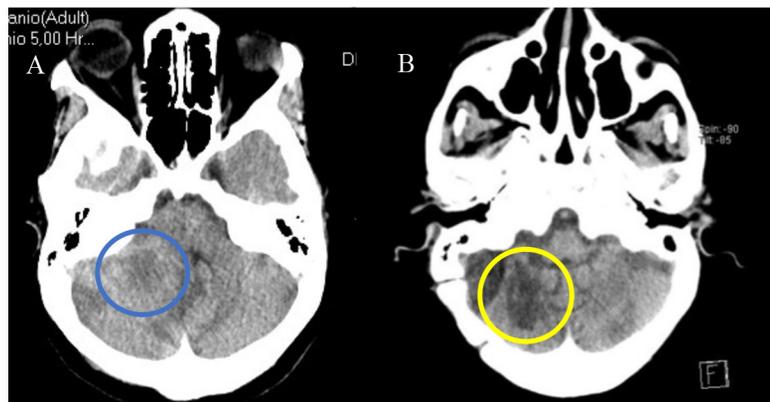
Right cerebellar lesion from Case 1, in cranial CT scan.
